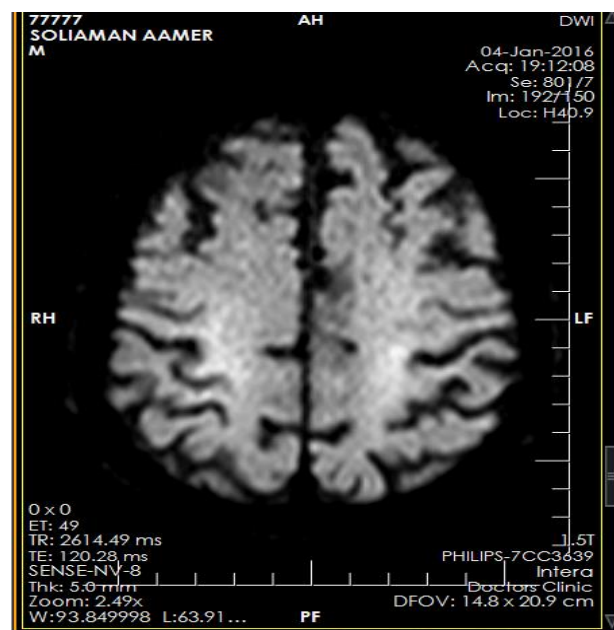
Axial MRI of the brain. Diffusion weighted imaging sequence showing non restricted signal at DWI for male patient 50 years old.
